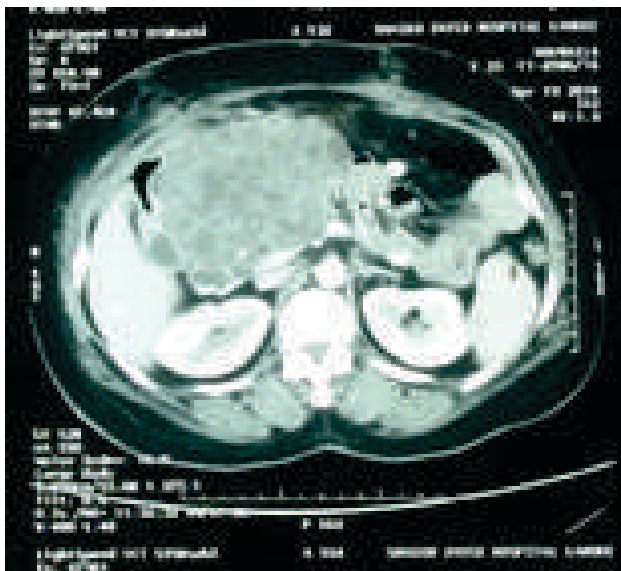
CT-Scan of a Patient Showing Serious Cystadenoma
